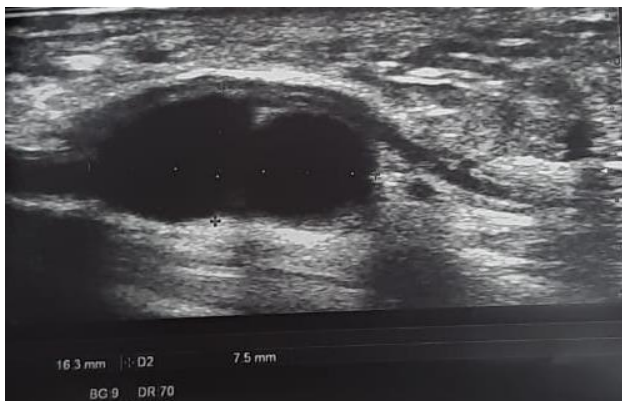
Ultrasound of the right ulnar nerve at the wrist level showing 16x8 mm cystic lesion compressing the ulnar nerve in the Guyon's canal.
